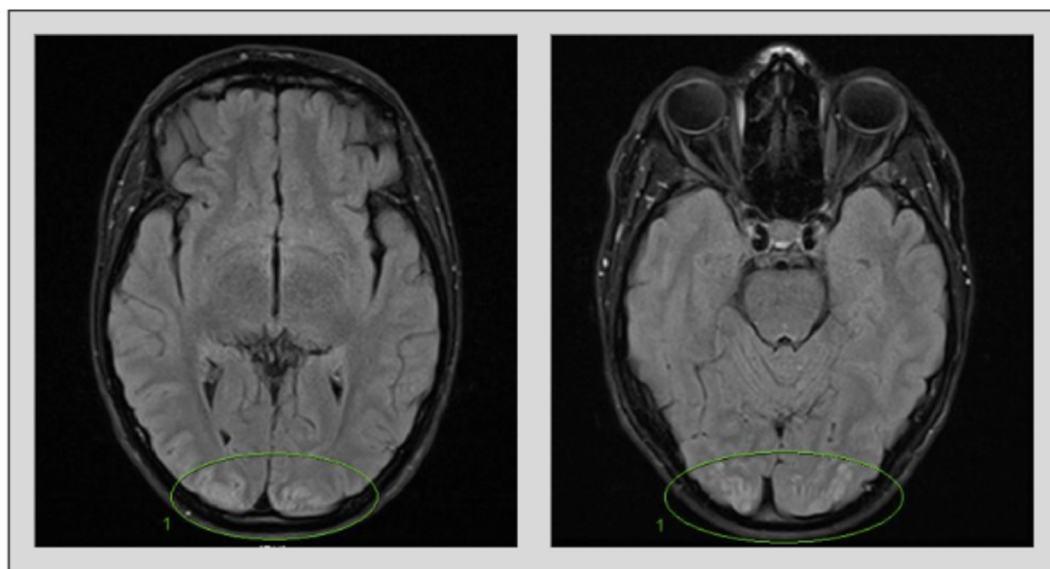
Subtle cortical and subcortical edema in both occipital and posterior parietal lobes best seen on the magnetic resonance imaging FLAIR sequences.
